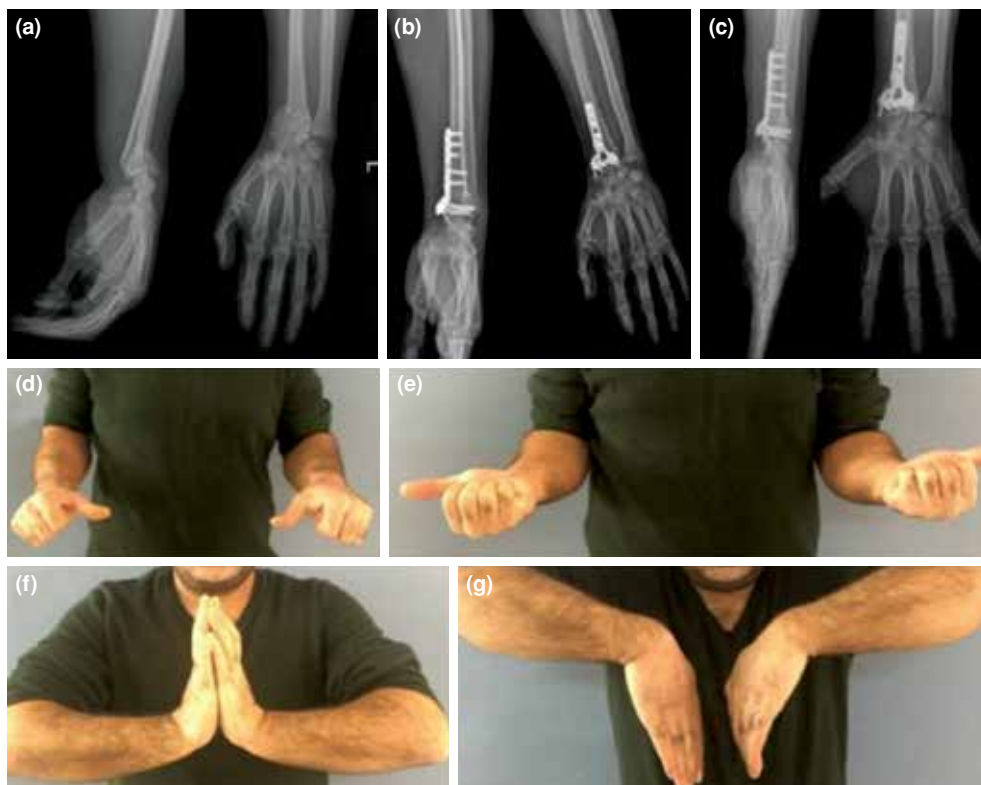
Pre-, early postoperative, and final follow-up radiographic images of wrist of a patient with volar locking plate (a-c). The clinical picture of the patient at final follow-up (d-g).
